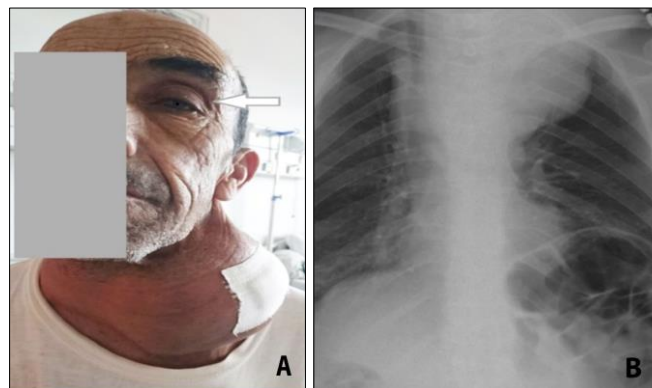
Patient presenting with a large cervical mass associated with Claude Bernard-Horner syndrome. A: Clinical representation showing ptosis, indicated by the black arrow. B: Chest X-ray of the same patient demonstrating a sizeable compressive cervico-mediastinal mass
